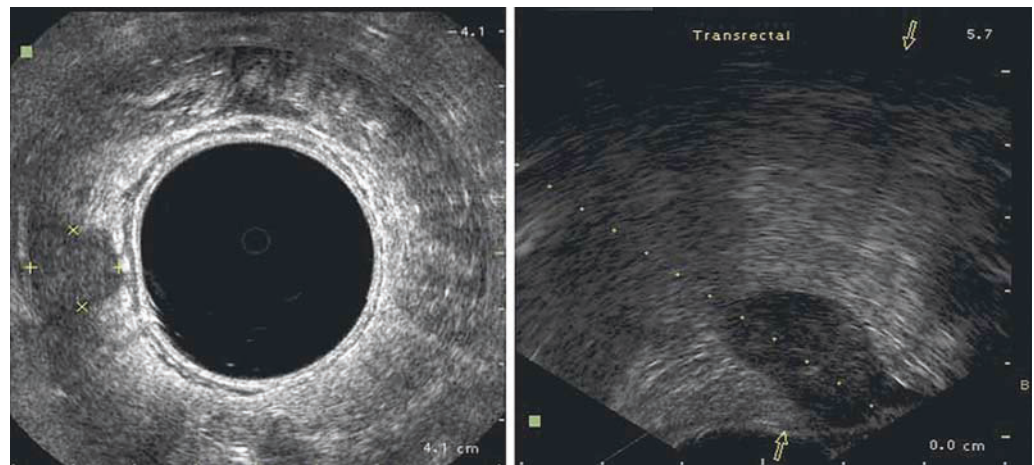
Left: Endorectal ultrasound (ERUS) image showing extrarectal lesion. Right: ERUS-guided biopsy of the lesion.
